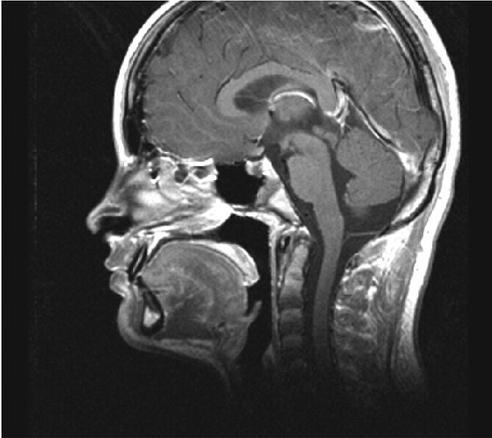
MRI (SE T1WI) in sagittal plane before and after administration of gadolinium contrast media (Gd CM). Solid part of tumors enhance homogeneously after administration of Gd CM. Note compression of surrounding structures. No communication between lesions is seen.
